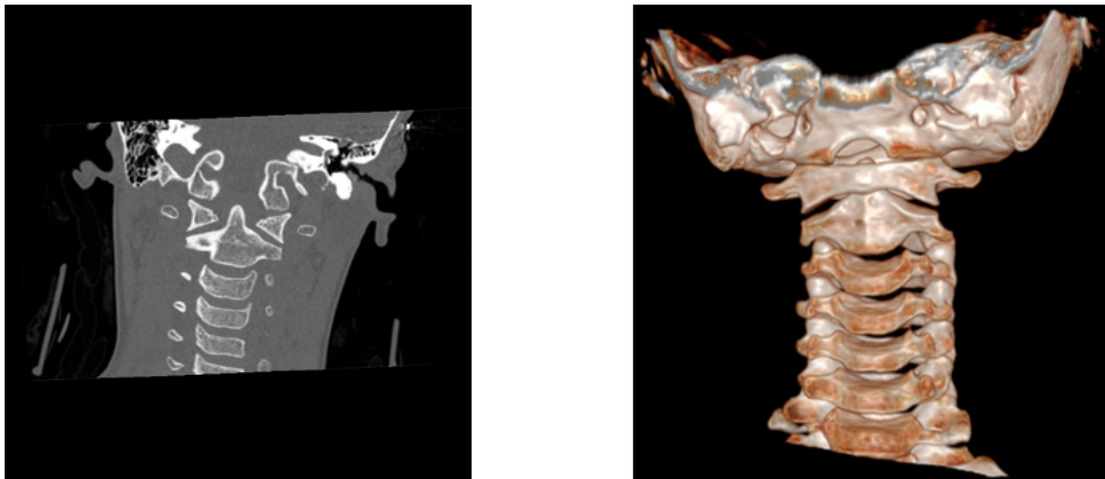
CT of cervical spine, confirming improved cervical alignment with no significant residual subluxation. As noted previously, otherwise normal vertebral alignment.
